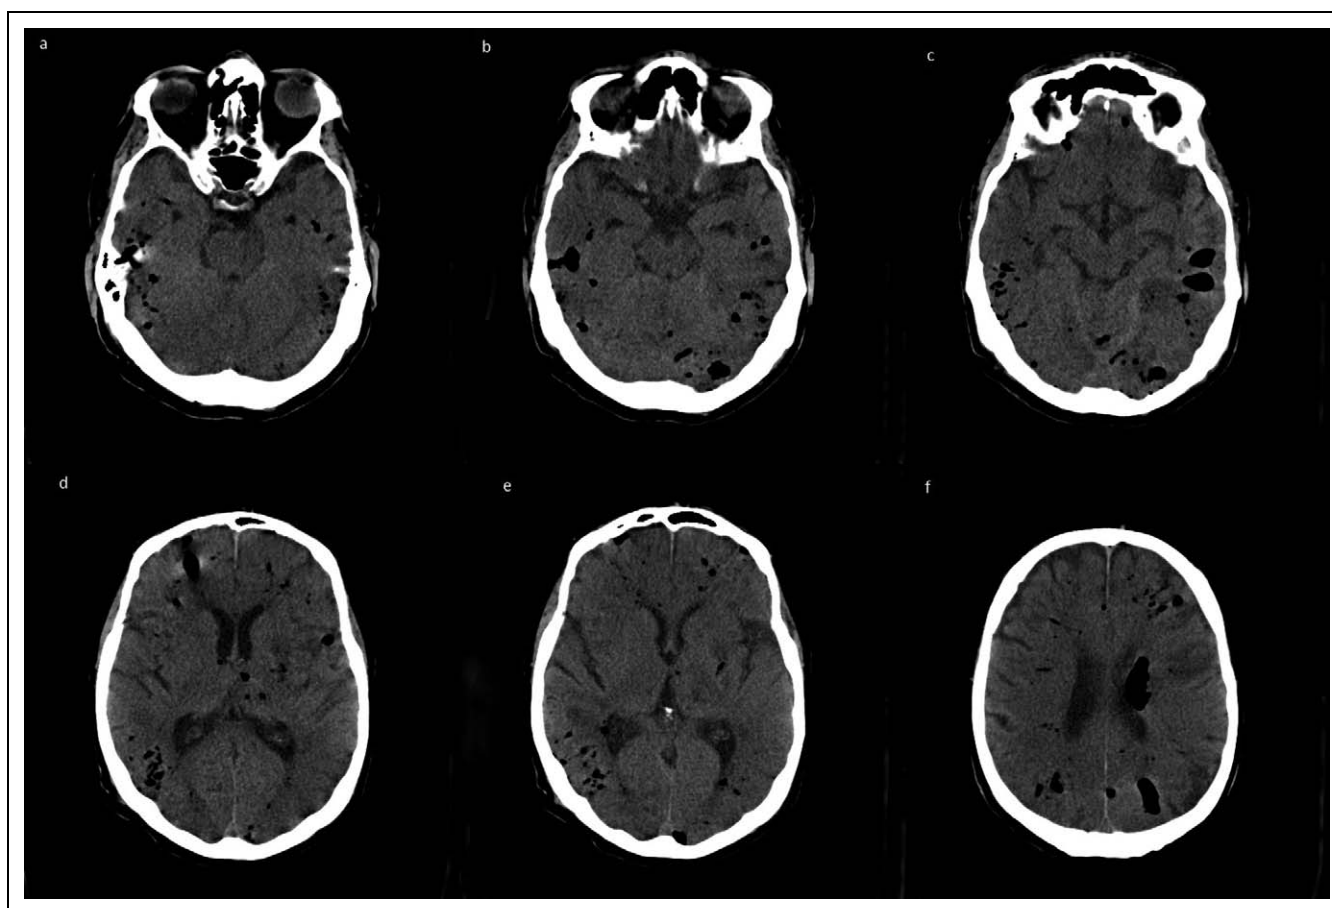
Noncontrast head computed tomography (CT) on the patient on hospital day 12 demonstrating extensive, multifocal intravascular pneumocephalus within the cortical vessels, dural venous sinuses, subarachnoid space, and within the cerebral parenchyma.
